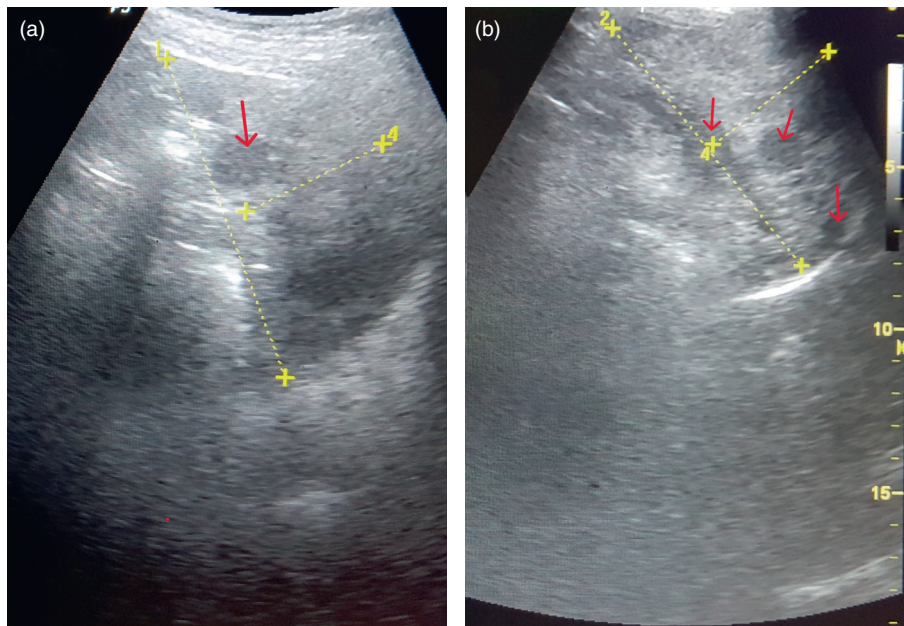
Abdominal ultrasonography showing splenic nodules among patients with SCD. (a) (left) Solitary intrasplenic nodule in a 14-year-old male with HbSS. Longitudinal view of the spleen on ultrasonography shows a round hypoechoic nodule close to the hilum (red arrow) and measures up to 2 cm. (b) (right) Transverse view of the spleen showing multiple hypoechoic nodules (red arrows) in a 24-year-old female with HbSS. SCD, sickle cell disease.
